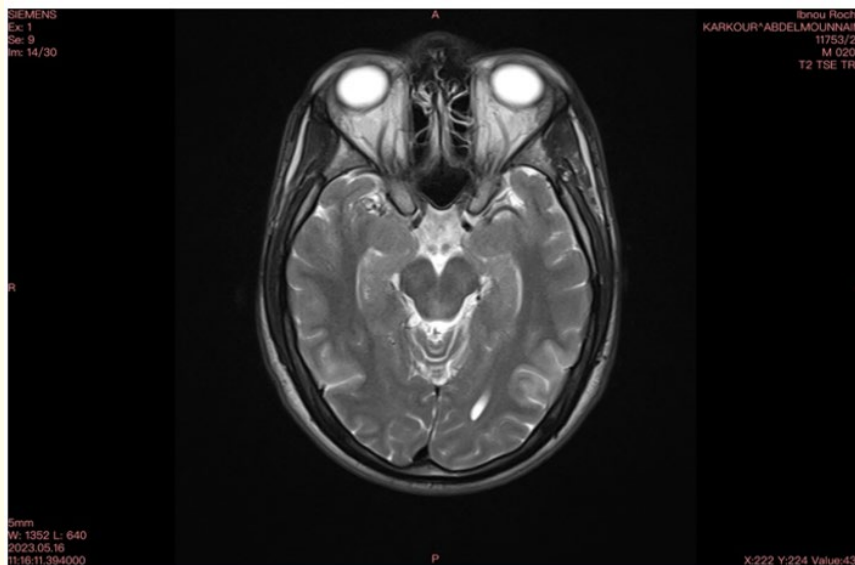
MRI showing bilateral parieto-occipital lesions with T2 hypersignal.
